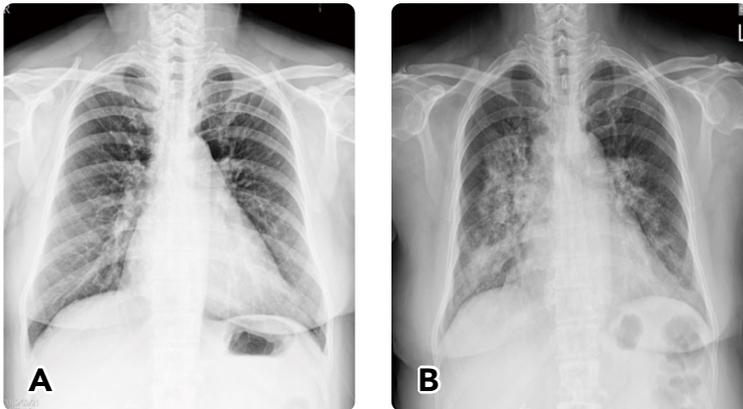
Baseline CXR(chest radiograph) two years ago ; Figure 1B . CXR upon arrival showed bilateral opacities
